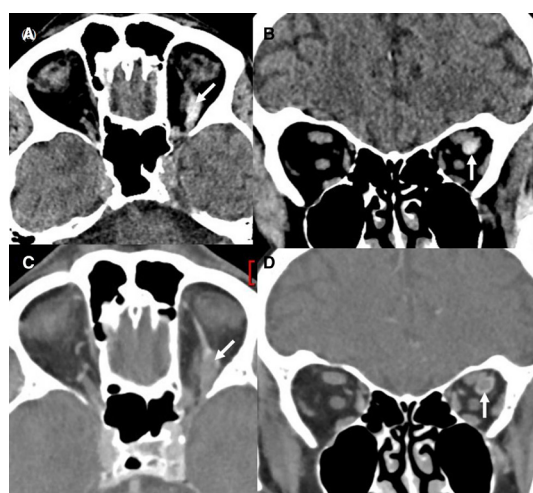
Non-contrast CT head (A, B) and CT angiogram (C, D), show dilated and dense superior ophthalmic vein (arrows) on left side in (A, B) and as a prominent filling defect (C, D).
